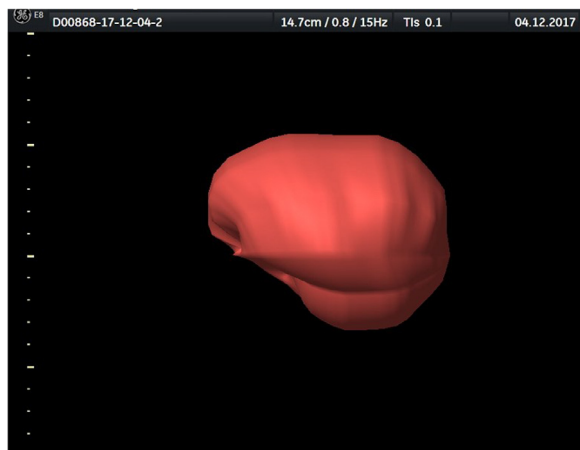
Example of a 3-D ultrasonographic image of the whole brain volume.
